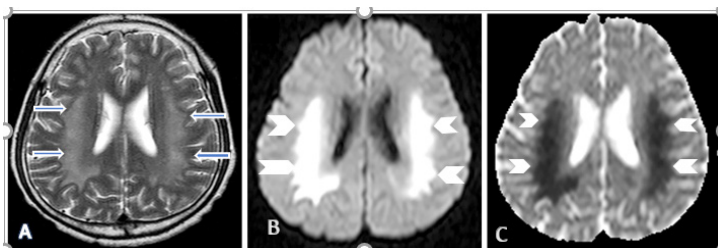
In a non-diabetic uremic patient, A) T2-weighted images demonstrate bilateral periventricular hyperintense involvement (arrows), and B) and C) show widespread diffusion restriction (arrowheads) in these areas due to cytotoxic edema. (13)
